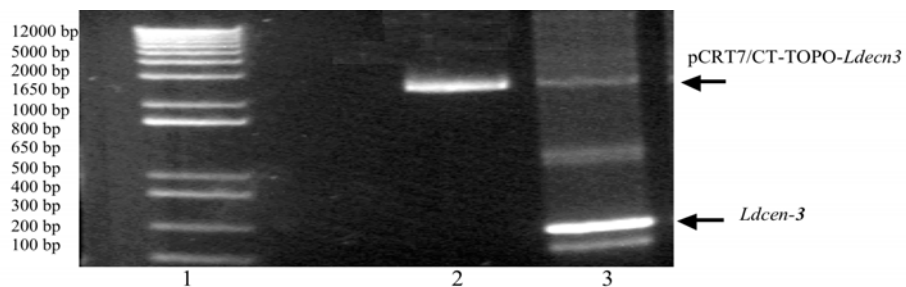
Confirmation of the presence of Ldcen-3 by PCR: The presence of Ldcen-3 was confirmed by PCR amplification using 5`AGA GGC ATT CGT GTT CG-3` forward and 5`AGG TTG ATC TCG CCA TCT TGA -3`reverse primers 1- ladder, 2- pCRT7/CT-TOPO-Ldcen3 as a control and not PCR result, 3- Ldcen-3 (PCR product).`
